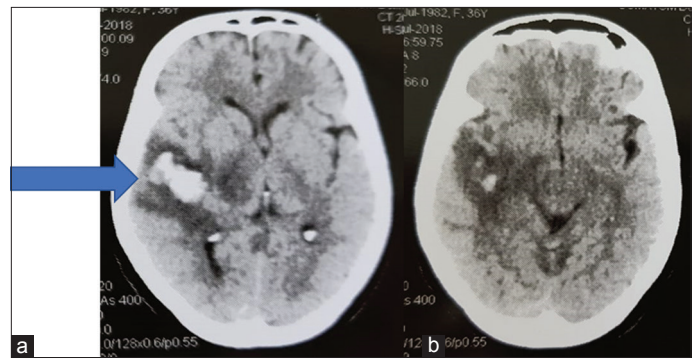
(a and b) Non-contrast computed tomography brain showing acute bleed in the right parietal lobe with surrounding edema and mass effect (arrow)
